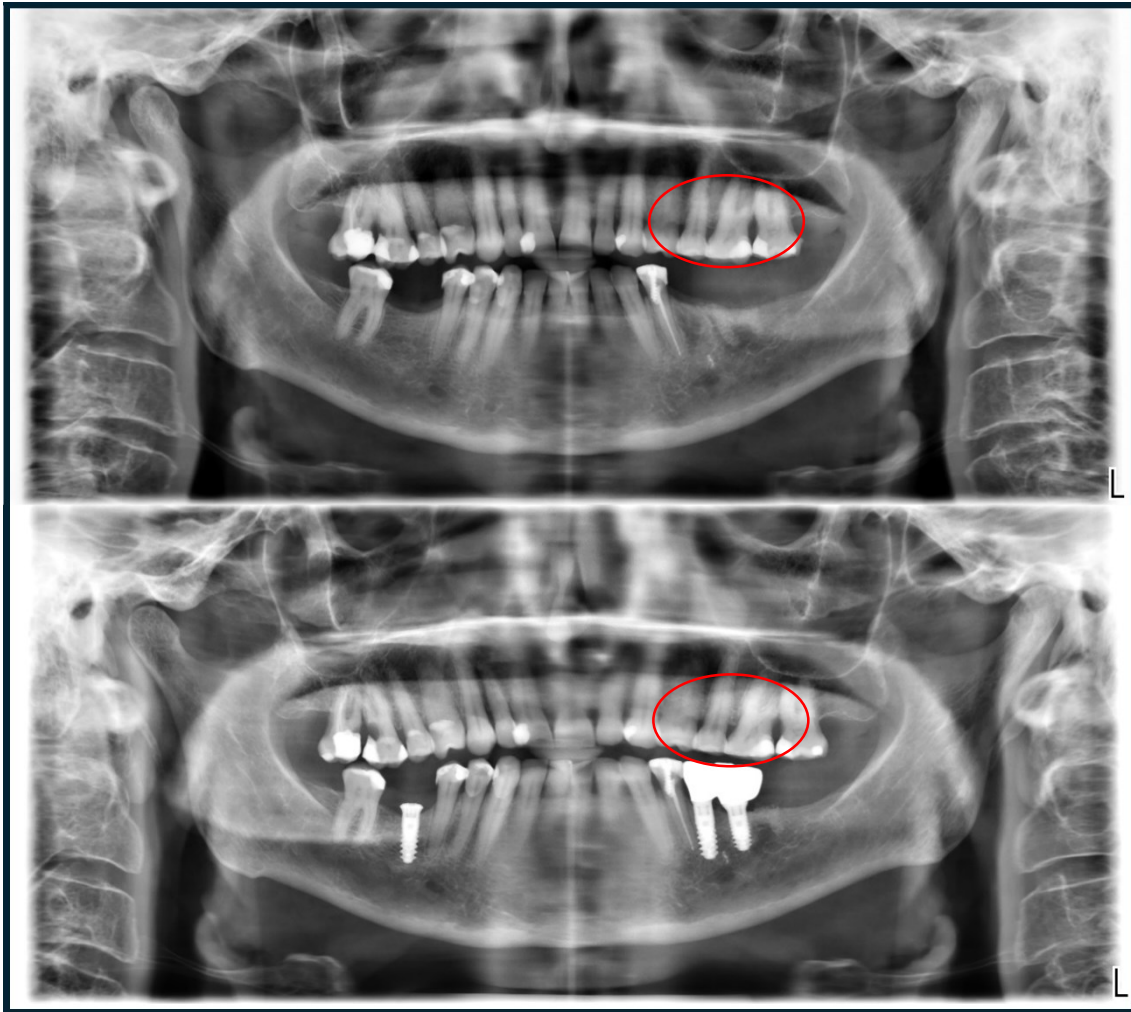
Patient SP5, orthopantomography comparison time 1 24/10/2023 (above), time 2 25/06/2024 (below)
